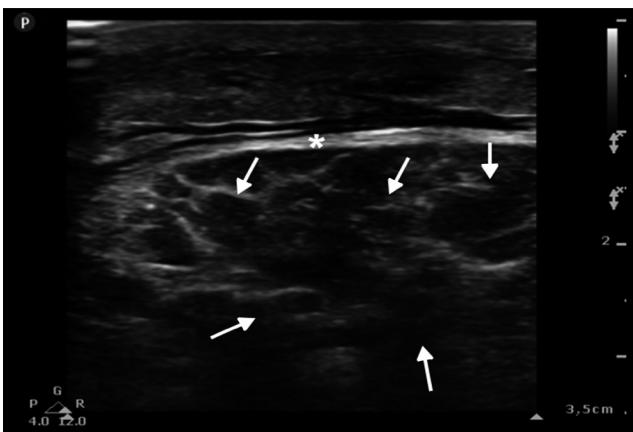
Ultrasound image in 2D of the left rectus femoris muscle in longitudinal section showing abundant anechoic areas, compatible with oedema (arrows), and increased diameter of the muscle fascia (*).
